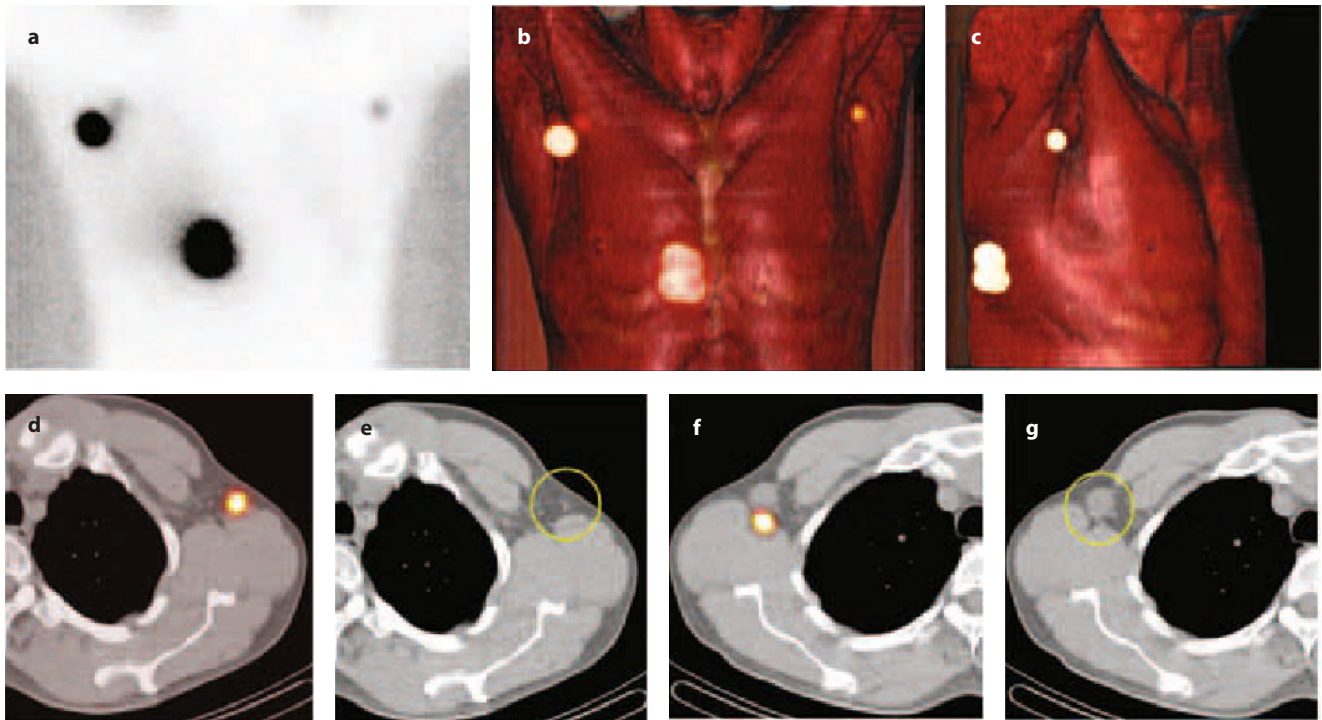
Patient with melanoma located in the back of the right torso. a Planar anterior view showing lymphatic drainage to both axillae, as better demonstrated by SPECT/CT with volume rendering for 3D display, respectively in the anterior and in the right oblique view (b and c). d–g Fused axial SPECT/CT section at two different levels, showing the location of radioactive lymph nodes, in the left axilla (d) and right axilla (f). The corresponding CT sections show that the hot lymph node in the left axilla corresponds to a normal-sized node (*yellow circle* in e), while in the right axilla the hot lymph node (of approximately normal size) is located posterior to a grossly enlarged, most likely metastatic, lymph node not visualized by lymphoscintigraphy (*yellow circle* in g)
